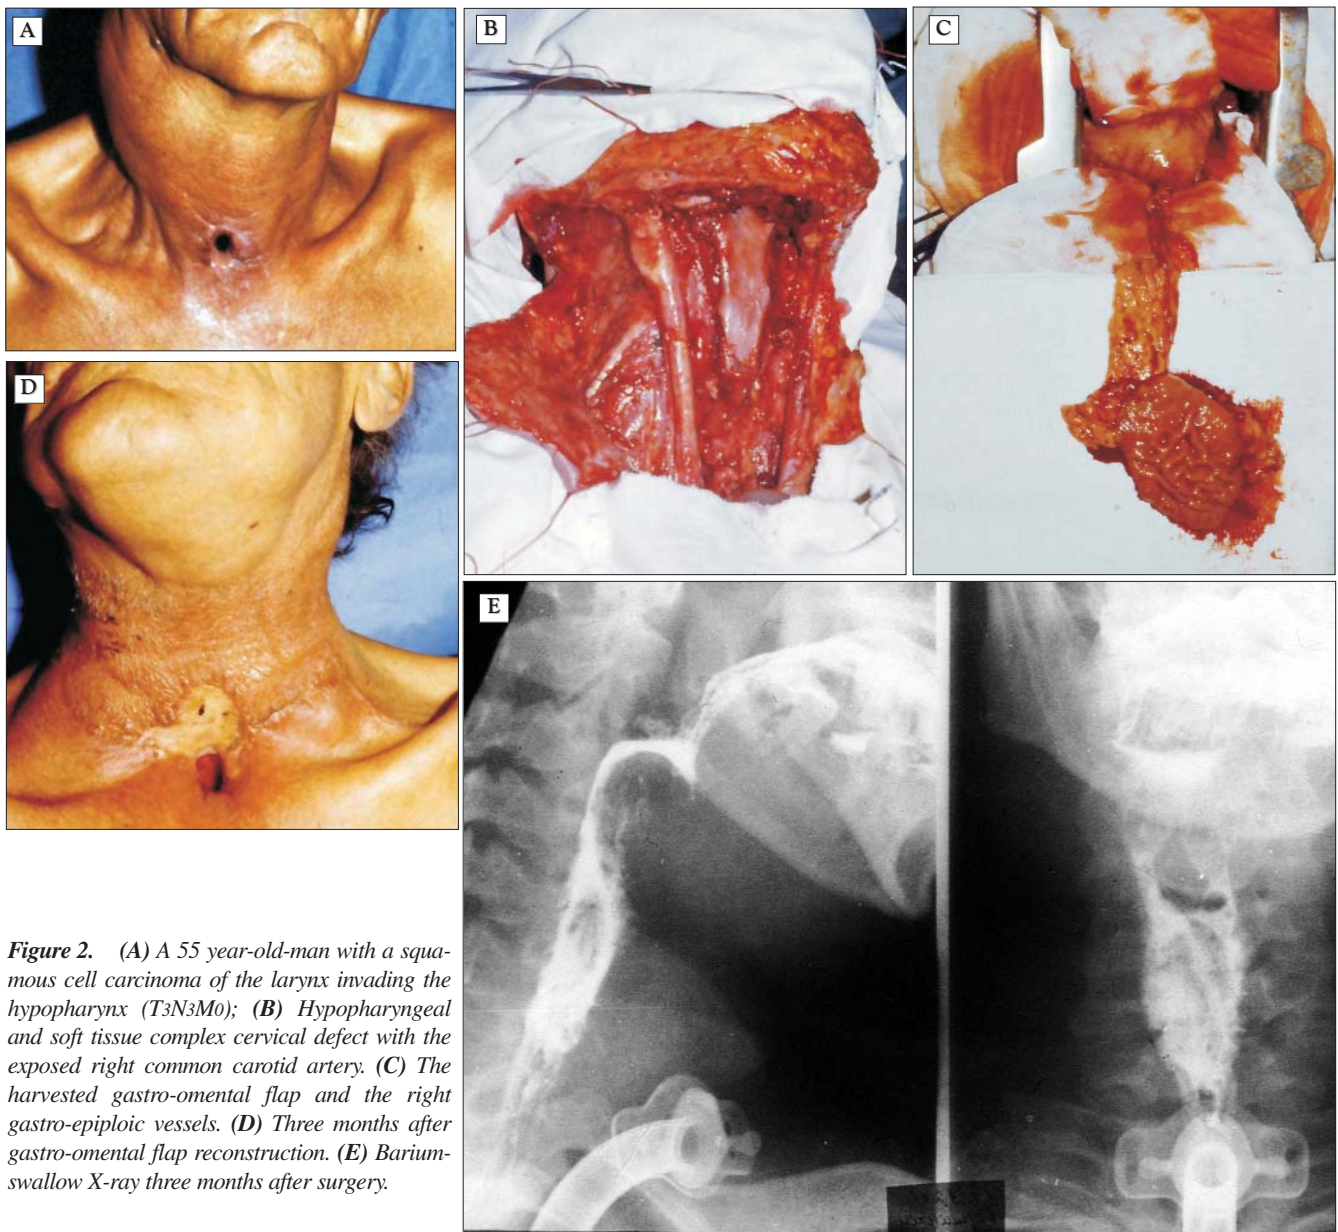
(A) A 55 year-old-man with a squamous cell carcinoma of the larynx invading the hypopharynx (T3N3M0); (B) Hypopharyngeal and soft tissue complex cervical defect with the exposed right common carotid artery. (C) The harvested gastro-omental flap and the right gastro-epiploic vessels. (D) Three months after gastro-omental flap reconstruction. (E) Barium-swallow X-ray three months after surgery.
